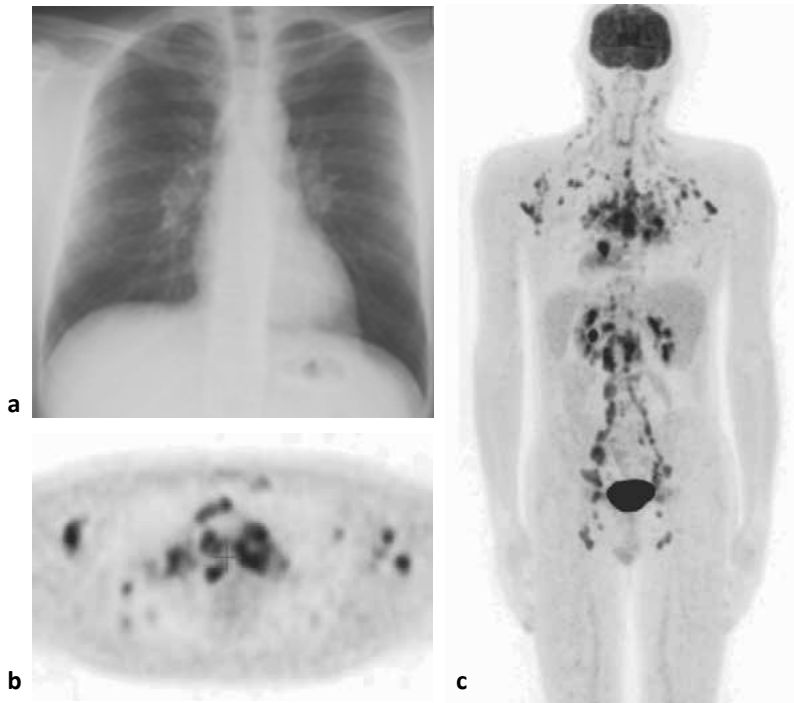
Example of a sarcoidosis patient with hidden muscle atrophy. A 32-year-old man with a history of sarcoidosis of 5 years has a BMI of 21.9 kg/m^2 and a FFMI of 14.9 kg/m^2 , indicating hidden muscle atrophy. ACE is 27 U/l , sIL2R 5053 U/ml and CRP 11 mg/l ; elevated sIL2R indicating inflammatory activity. DLCO is 69%, FEV1 52% and FVC 62% of predicted, indicating severe respiratory functional impairment. a. Chest radiograph shows only mild abnormalities consisting of bilateral hilar lymphadenopathy without parenchymal involvement (stage I). b. PET image of the total body shows inflammatory activity indicated by increased FDG uptake in multiple lymph nodes and to a lesser extent in pulmonary parenchyma bilaterally. c. PET image at thoracic level shows mildly increased FDG uptake in the pulmonary parenchyma bilaterally and extensive uptake in axillary and mediastinal lymph nodes. ACE, angiotensin-converting enzyme; BMI, body mass index; CRP, C-reactive protein; DLCO, diffusing capacity for carbon monoxide; ^{18}F -FDG, fluorine-18-fluorodeoxyglucose; FEV1, forced expiratory volume in 1 s; FFMI, fat-free mass index; FVC, forced vital capacity; PET, ^{18}F -FDG positron emission tomography/computed tomography; sIL2R, soluble-IL2-receptor.
